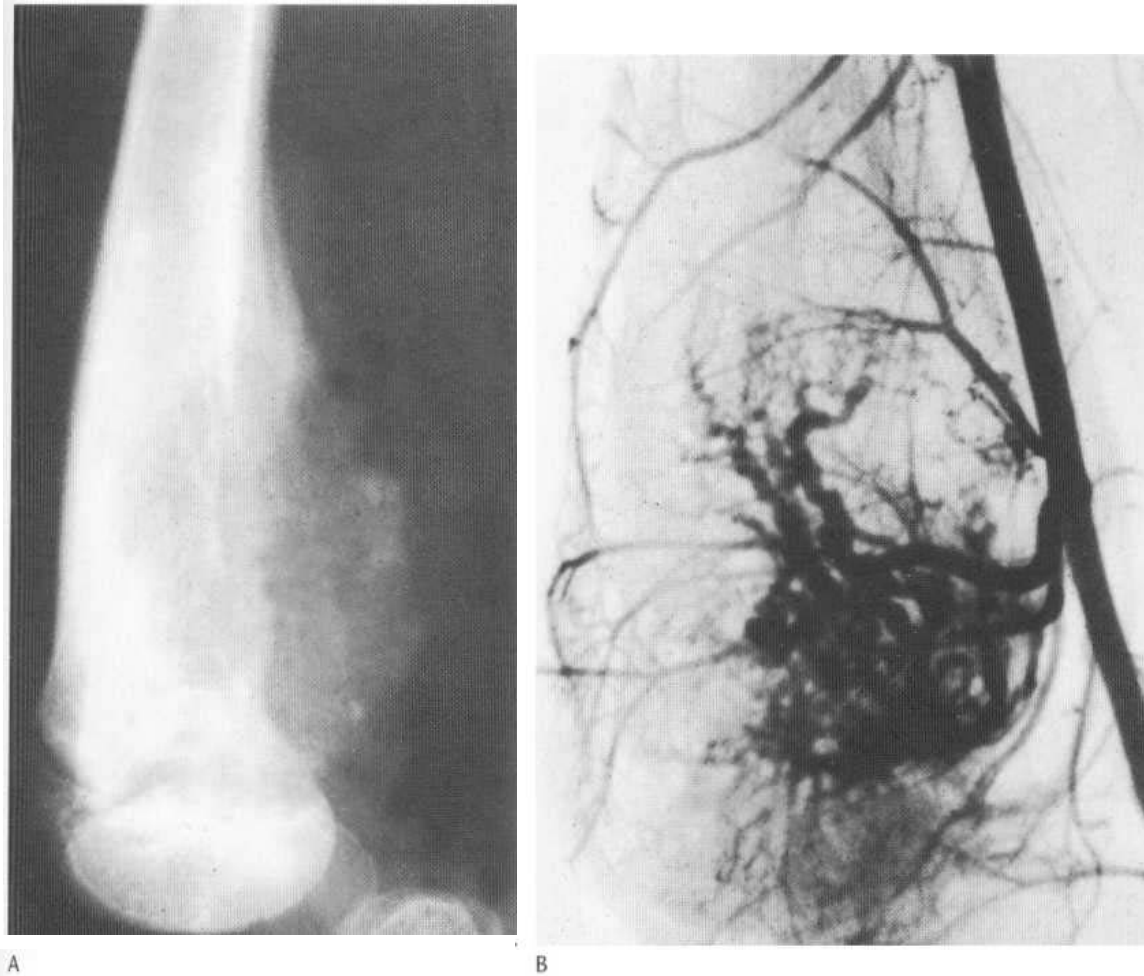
Telangiectatic osteosarcoma of the distal femur. (A) A predominantly radiolucent defect is shown on conventional radiograph which angiographically (B) is shown to contain large, tortuous, pathological vessels. Well-marked Codman's triangles are present together with sclerosis in the shaft of the bone, surrounding the lesion.
